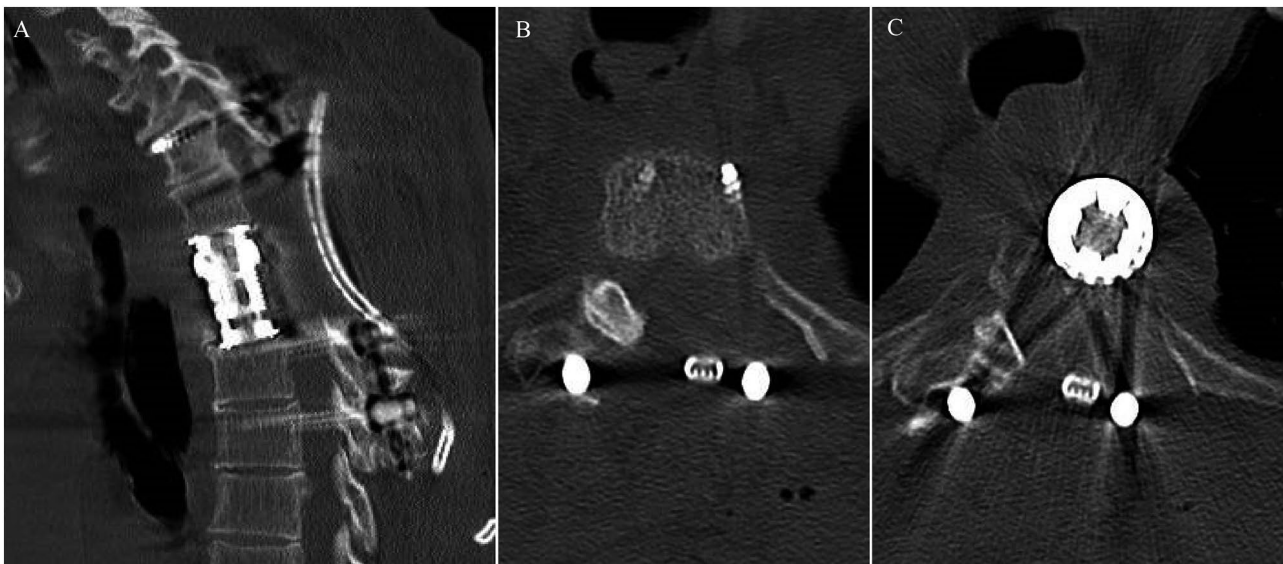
Sagittal (A), axial T3 level (B), and axial T4 level (C) slices from the patient's post-operative CT scan demonstrating the two-level sagittal anterior column reconstruction and unresected rib heads at both transpedicular levels on the approach side. The lateral vertebral body at T4 had been eroded by infection pre-operatively
